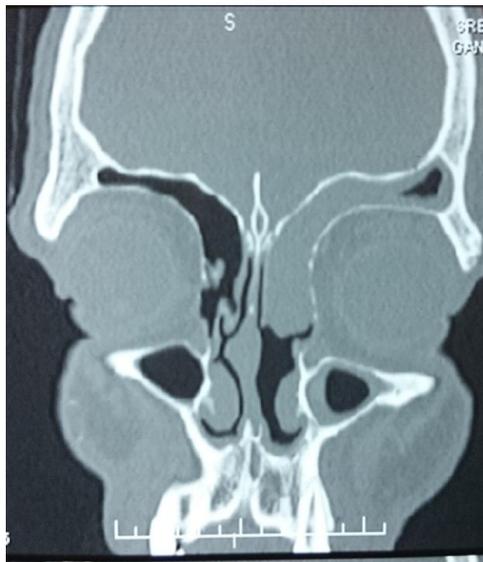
Pre op CT picture showing complete opacification of {L} frontal sinus extending to the nose
